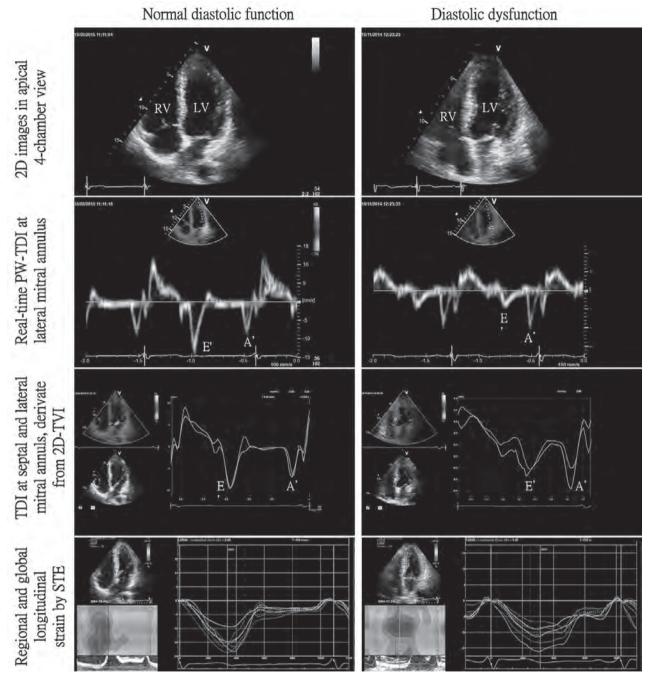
Demonstration of tissue Doppler imaging and speckle tracking echocardiography.
